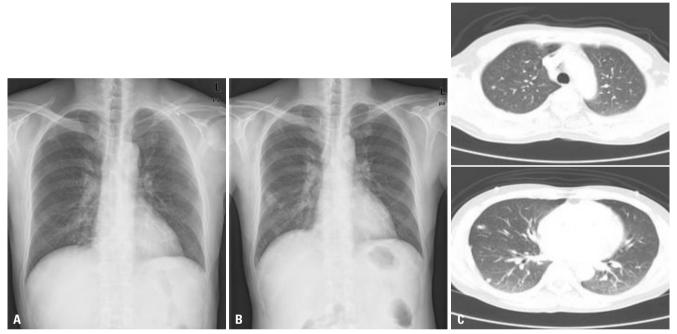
(A) Plain chest radiograph within normal limits. (B) Plain chest radiograph showing newly developed multiple nodular lesions in the right lower lung field. (C) Chest CT scans showing multiple nodular lesions in the right and left lower lobes of the lung.
